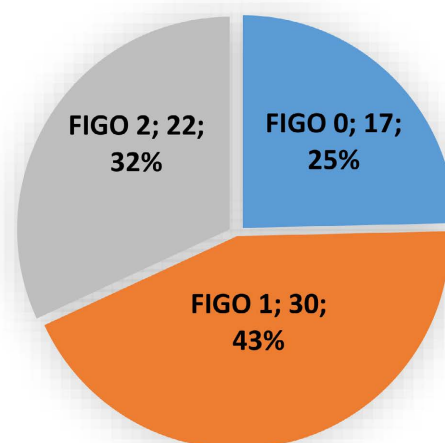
Classification of fibroids in patients undergoing hysterosonography at CHRACERH from 1st of January 2020 to the 31st of July 2022. FIGO 0 = Pedunculated intracavitary fibroid; FIGO 1 = Fibroid <50% intramural; FIGO 2 = Fibroid > 50% intramural.
